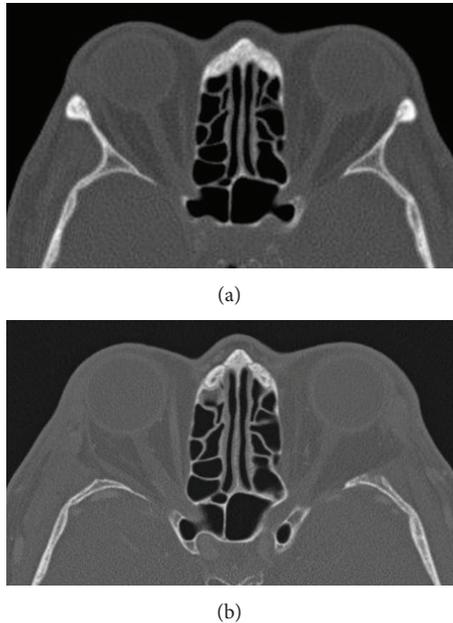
Preoperative (a) and postoperative (b) axial CT scan of the orbit. Note the missing lateral orbital wall after bony decompression without repositioning of the orbital rim.
